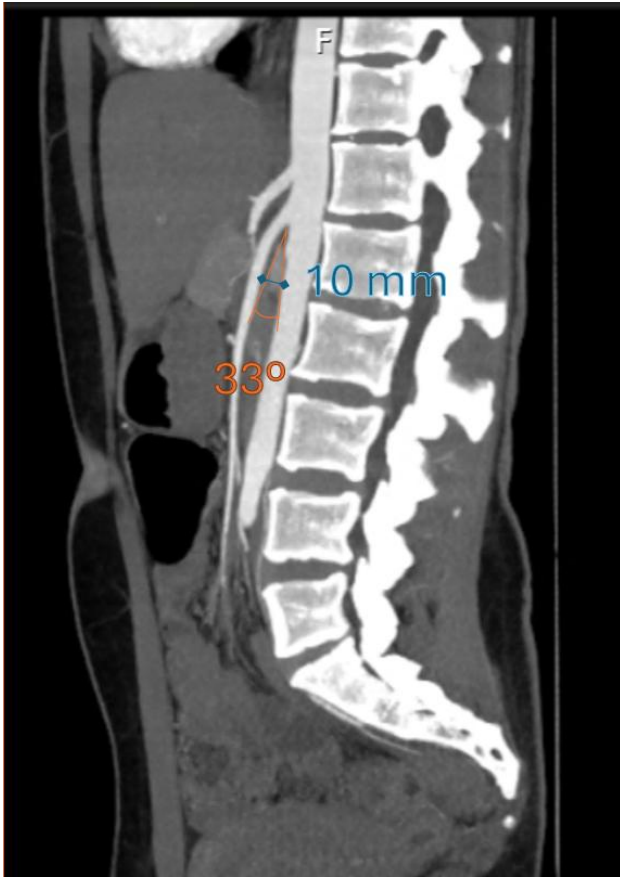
Sagittal MRI/angiographic reconstruction demonstrating reduced aortomesenteric angle (33°) and aortomesenteric distance (10 mm), consistent with compression of the third portion of the duodenum.
